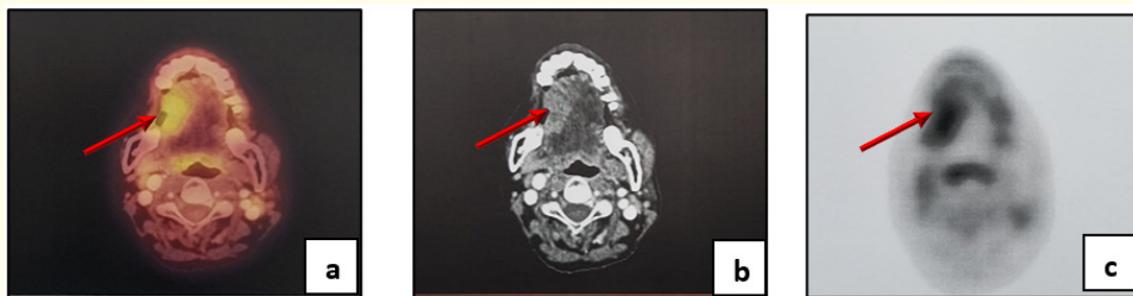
PET/CT scan demonstrated a metabolically active primary lesion involving the anterior right lateral tongue with midline extension (red arrow) along with metabolically active, mildly enlarged cervical lymph nodes.
